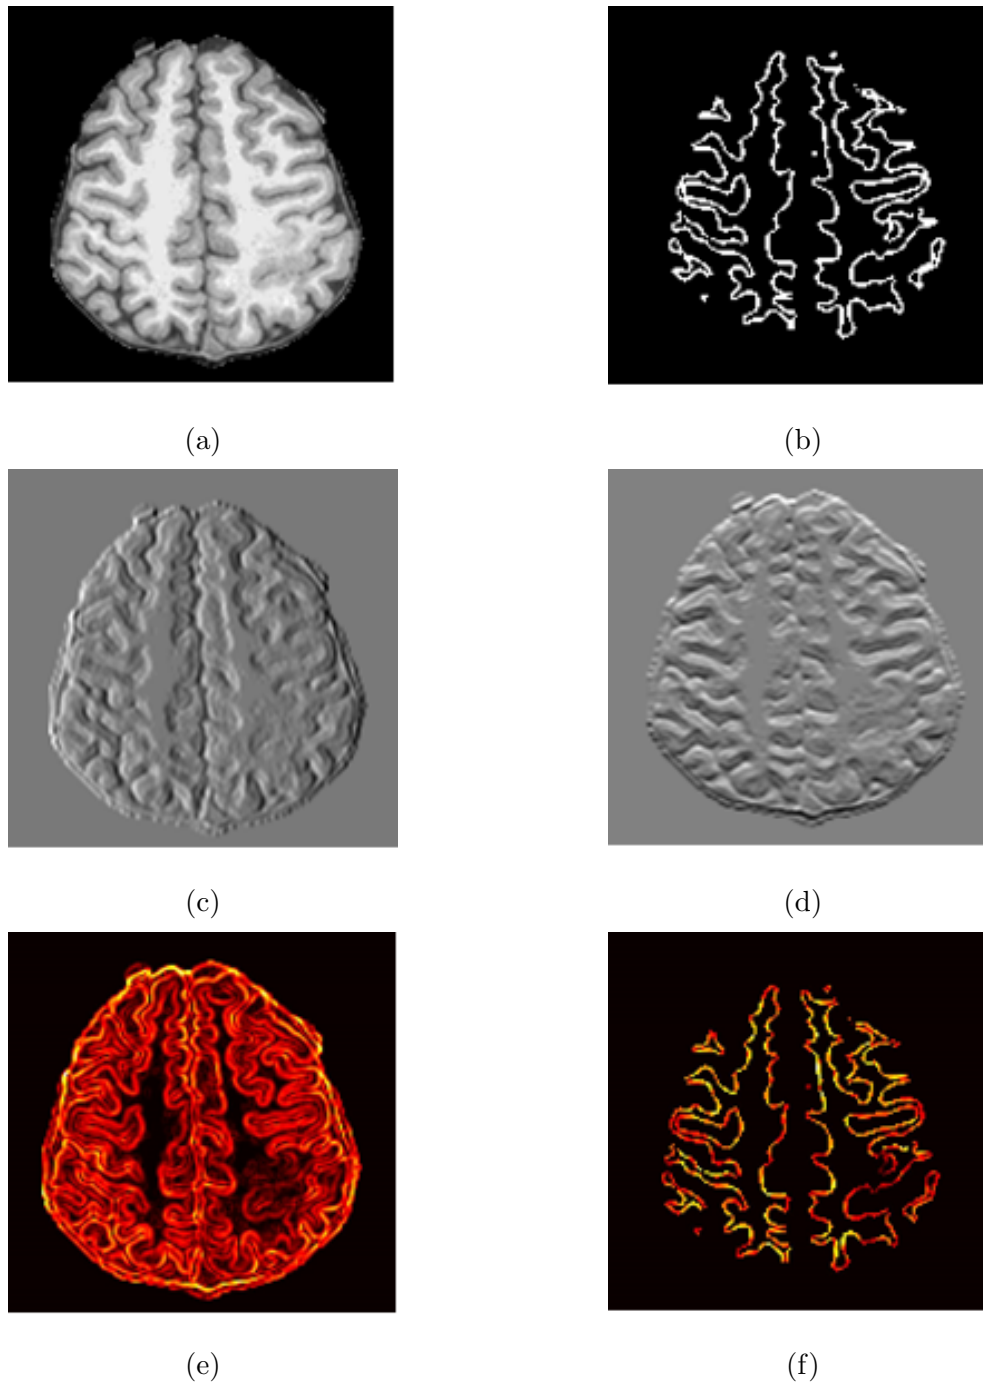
(a) Original T1-weighted image, (b) Sample interface mask generated, (c) Directional gradient along x-axis ( $G_x$ ), (d) Directional gradient along y-axis ( $G_y$ ), (e) Gradient magnitude of complete image, and (f) Interface mask was used to segment regions of the gradient magnitude, producing the gradient magnitude of the interface.
